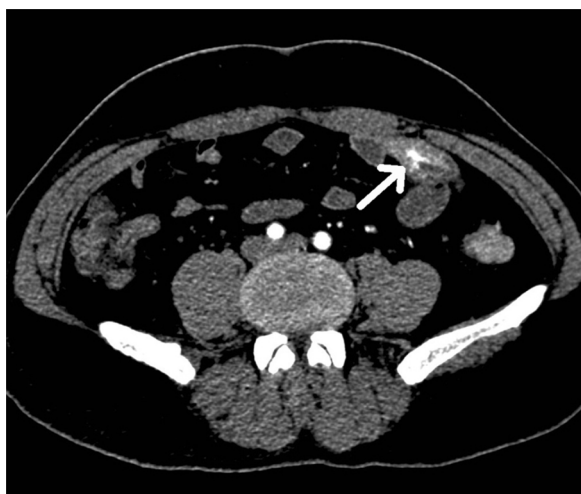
Axial section of CT abdomen (arterial phase) showing hypervascular lesion in ileum.
